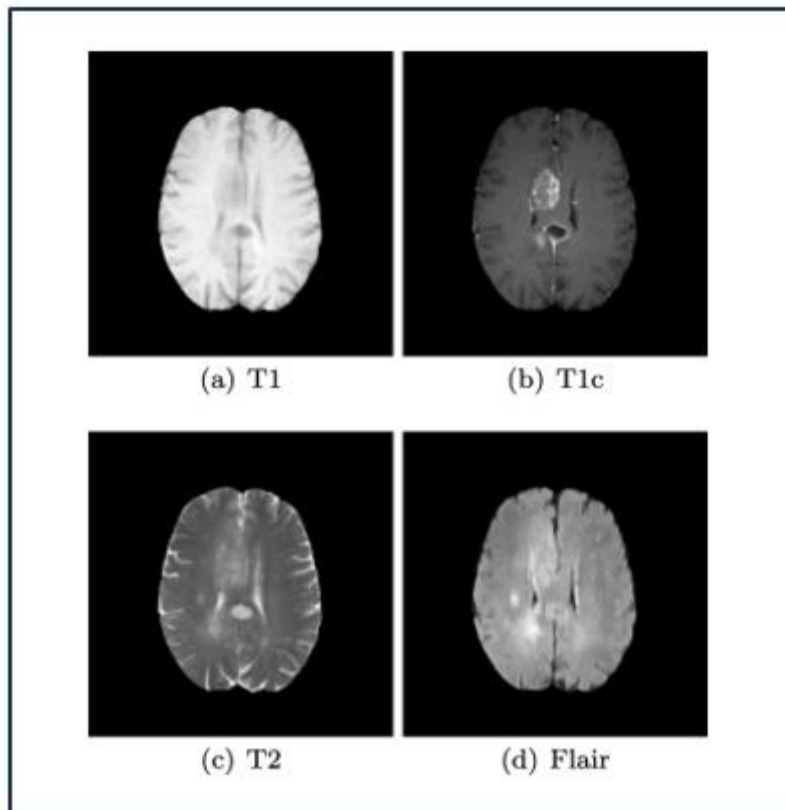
MRI Brain Dataset Images
